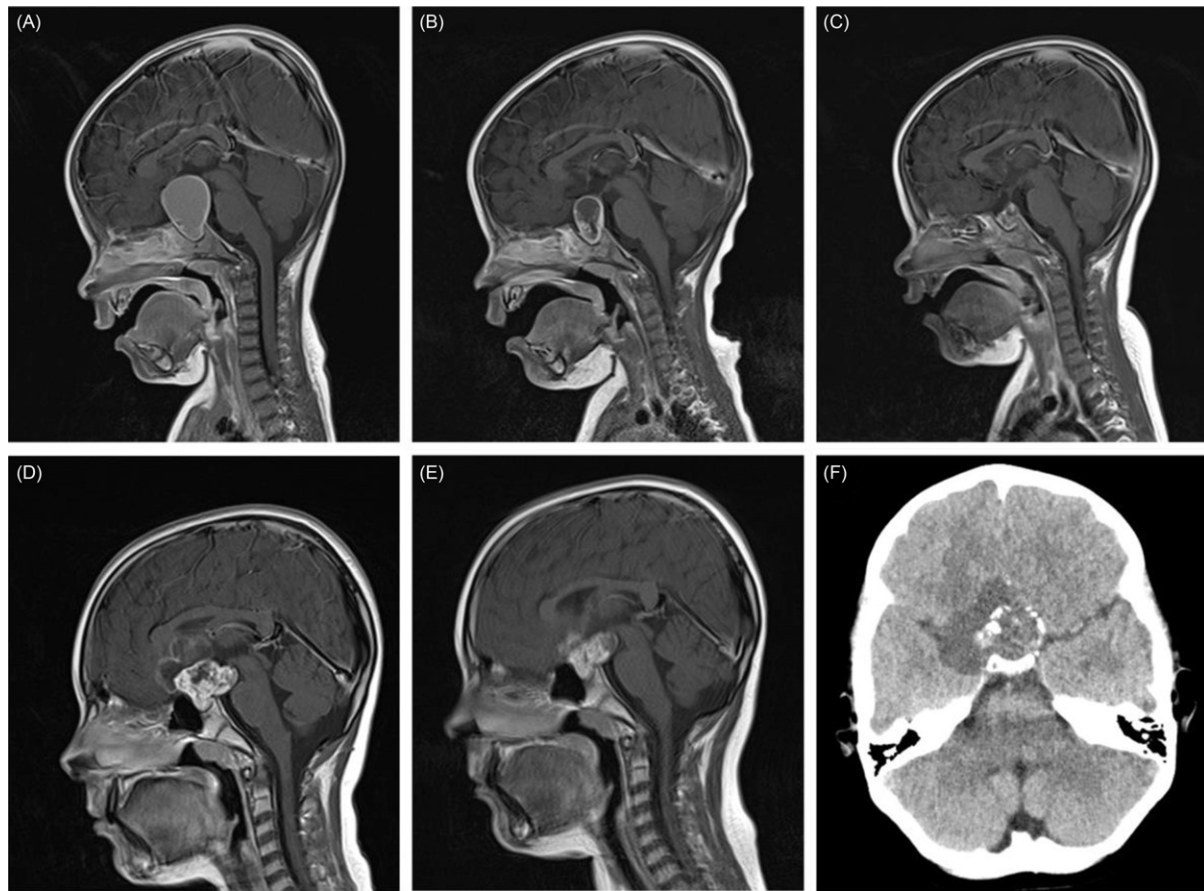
Imaging of craniopharyngiomas. Figs.(A)–(C) demonstrate sagittal T1-weighted, gadolinium-enhanced MR images of cystic adamantinomatous craniopharyngioma in a 1-year-old male. The preoperative image (A) demonstrates the suprasellar cyst clearly and avidly enhancing cyst wall. The hyperintense signal characteristics of the intracystic fluid are different to surrounding CSF, suggesting a proteinaceous consistency. Image (B) demonstrates a reduction in cyst size following Ommaya reservoir insertion and aspiration. Cystic reaccumulation despite intracystic therapy resulted in open debulking surgery. The postoperative scan (C) shows significant reduction in lesion size. By contrast, the preoperative (D) and postoperative (E) sagittal T1-weighted, gadolinium-enhanced MR images from another child are of solid/cystic adamantinomatous craniopharyngioma. While a differential diagnosis of this lesion could include a low-grade glioma, the calcium deposits around the periphery of the lesion on CT imaging (F) are in keeping with a craniopharyngioma. Given the degree of postoperative residual tumor involving the hypothalamus (E), the patient subsequently received focal proton beam radiotherapy.
